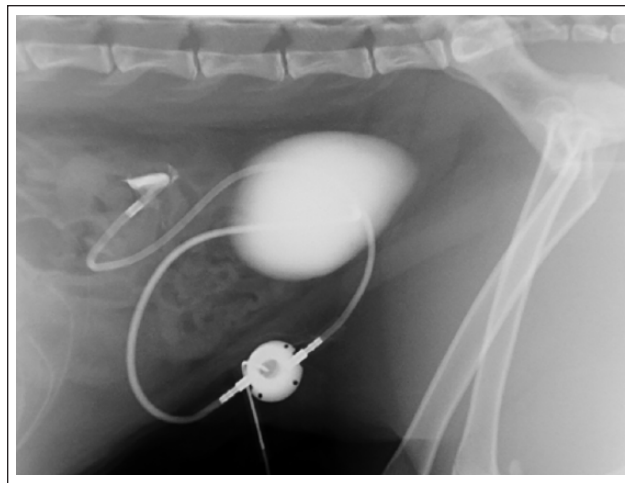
Lateral abdominal radiograph demonstrating 90° rotation of the subcutaneous ureteral bypass port within the subcutaneous tissue
